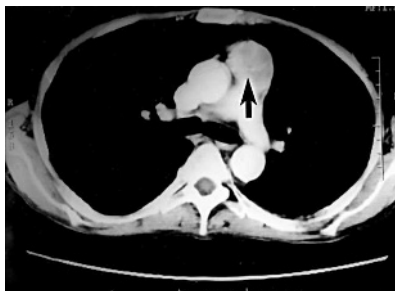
Contrast enhanced computed tomogram of chest showing a well circumscribed mass in the anterior mediastinum.
